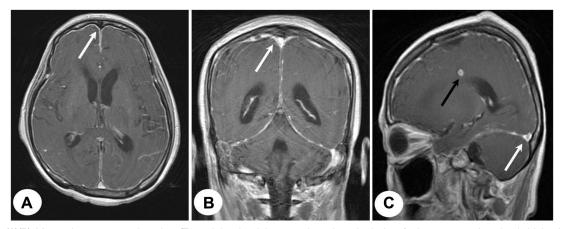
(A)(B) Magnetic resonance imaging (T1-weighted axial, coronal, and sagittal views) shows extensive dural thickening with enhancement (*white arrow*). (C) Round ring-like enhancement in the left centrum smiovale (*black arrow*).
